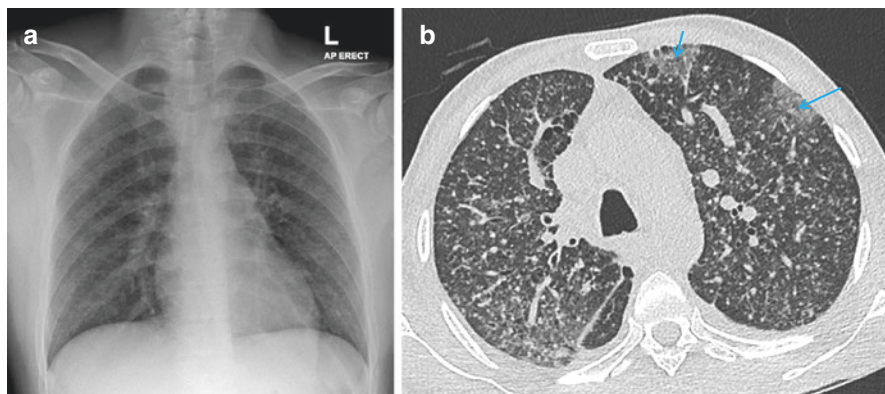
(a) AP chest radiograph demonstrates subtle diffuse nodularity throughout both lungs, giving the lungs an overall abnormal texture in miliary TB. (b) Axial CT Lung slice confirms a miliary pattern of nodularity. Miliary nodules do not conform to the typical distribution of peri-lymphatic, tree-in-bud or centrilobular nodules. Interestingly, this patient with confirmed TB also tested positive for COVID-19. Note the well defined peripheral ground glass opacities in the anterior aspect of the left upper lobe (blue arrows)
